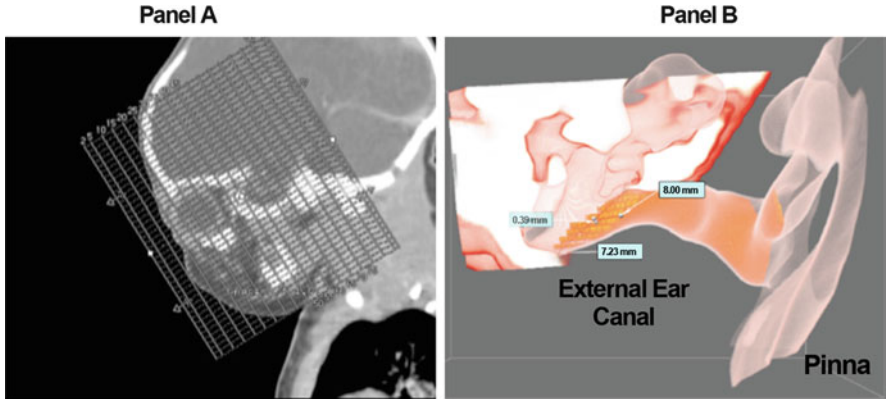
(a) A CT image of the head of a newborn showing the individual planar “slices” and the spacing (1 mm) between the “slices.”(b) A three-dimensional reconstruction (Dextroscope, Inc.) of the left middle ear, external ear canal, and pinna using the CT images in (a) and automatic segmentation
